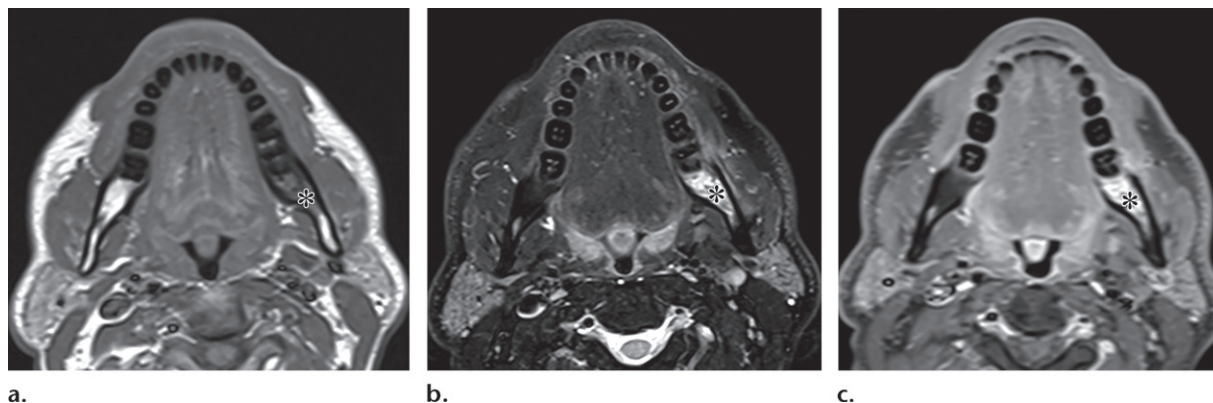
Acute osteomyelitis of the mandible. Axial T1-weighted (a), T2-weighted (b), and contrast-enhanced T1-weighted (c) MR images demonstrate signal intensity changes and enhancement of the bone marrow of the mandible (*).
